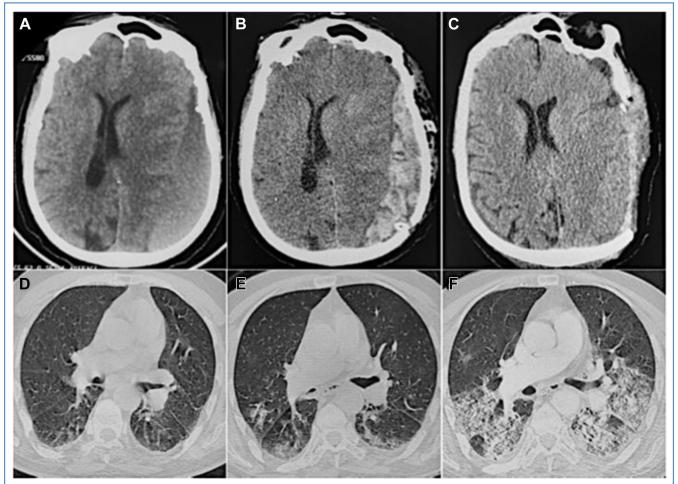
Computed tomography changes of the brain (A-C) and lung lesions (D-F) during the hospitalization of our case.
